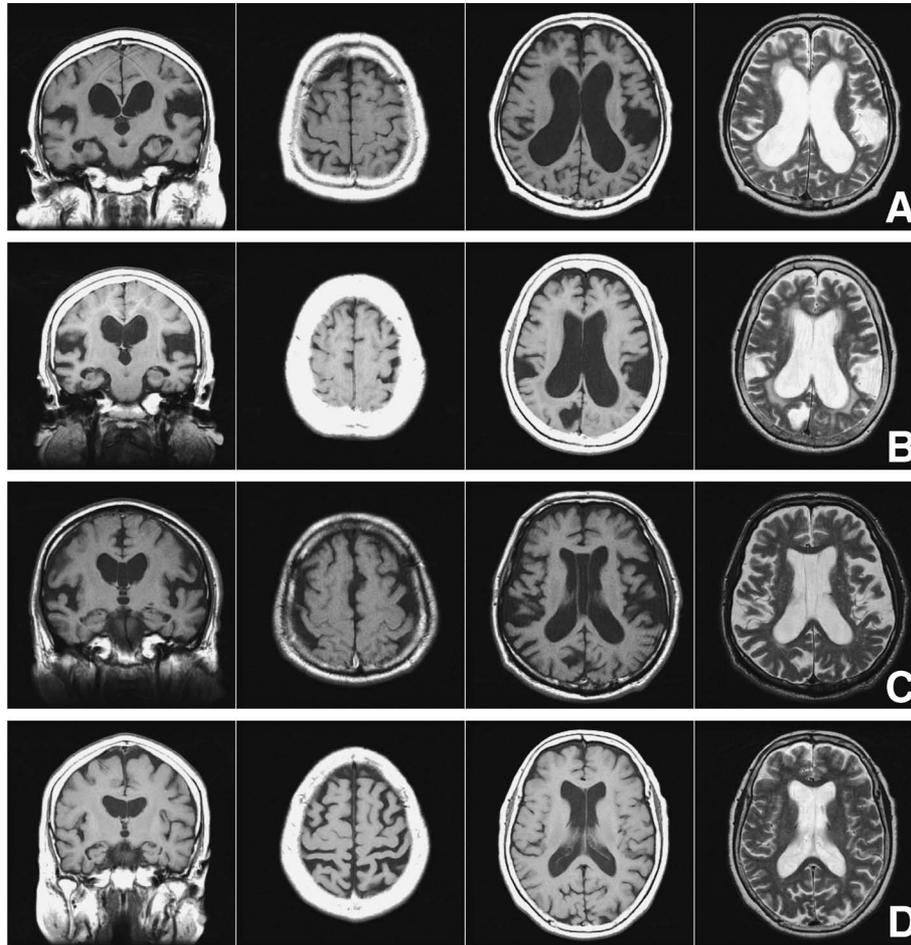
Magnetic resonance imaging (axial section): Examples of narrowing of the sulci with focal dilation.
